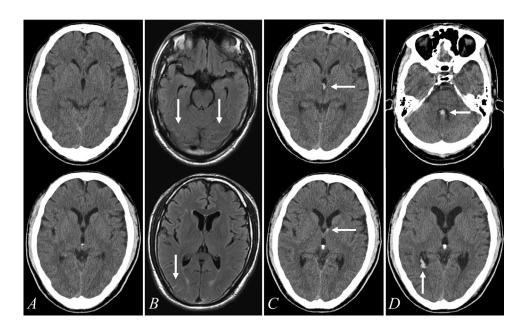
Initial computed tomography (CT) displays normal findings (A). The same-day magnetic resonance imaging (MRI) shows a subarachnoid hemorrhage in the bilateral occipital lobe (B, arrows). The next-day CT reveals bleeding, primarily in the third ventricle (C, arrows). 12 days after the initial bleeding event, CT reveals a third intraventricular bleeding event in the fourth ventricle and the lateral ventricle with intracranial ventriculomegaly (D, arrows)
